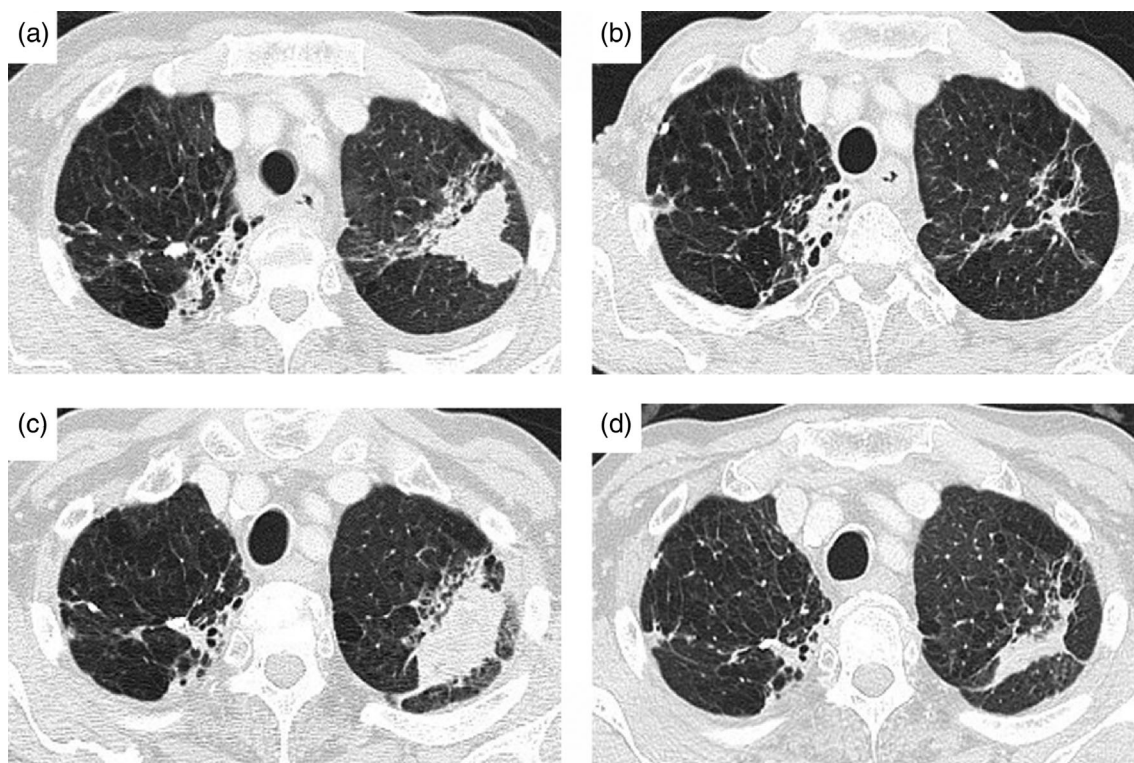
Chest computed tomography (CT) scans of the tumor in the left upper lobe. (a) CT scan before the initiation of palliative radiation therapy (RT) to the metastatic sites. (b) CT scan taken three months after the initiation of RT showed a reduction in the tumor size at the nonirradiated region. (c) CT scan taken 26 months after the initiation of RT showed regrowth of the tumor. (d) CT scan taken after three courses of pembrolizumab showed a partial response to the treatment
